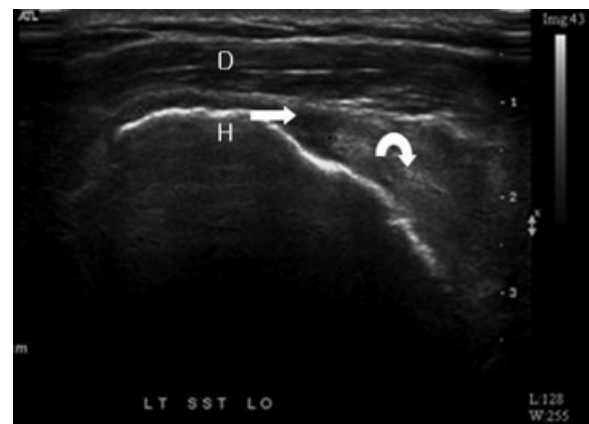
Longitudinal ultrasonography shows tendon nonvisualization, indicating a full thickness tear of the supraspinatus tendon (arrow). The retracted tendon end is detected (curved arrow). The overlying deltoid muscle (D) is seen on the underlying humerus (H).
